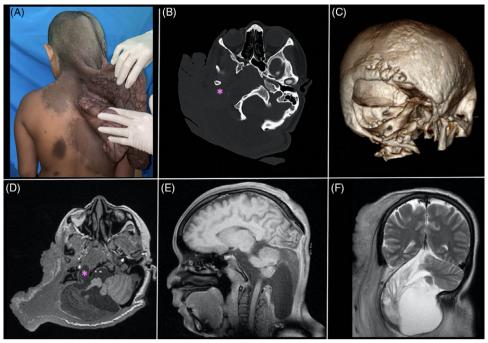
(A) View of the patient from the back, showing a large cutaneous-subcutaneous lesion on the right posterior neck, shoulder, and upper back; also seen are hyperpigmented patches in the posterior trunk; (B) cranial CT, bone window, showing a calvarial defect in the right occipital area and obliteration of the right external auditory canal and adjacent bony structures (asterisk); (C) 3D reconstruction of the cranial CT showing the occipital calvarial defect and intact upper cervical vertebrae; (D) axial sections of contrast cranial MRI, T1 sequence, showing the dysplastic right cerebellar hemisphere herniating through the calvarial defect, along with dysplastic parts of the medulla and middle and inferior cerebellar peduncles. There was also a right jugular foramen meningocele extending to the right carotid space (asterisk); (E) sagittal sections of cranial MRI, T1 sequence, showing the inferior extent of the encephalocoele down to the soft tissues at the C4 spinal level; (F) coronal sections of cranial MRI, T2 sequence, showing the dysplastic right cerebellum within the encephalocoele. These cranial imaging findings were seen in the background of a large, fungating, multilobulated, mildly enhancing soft tissue lesion in the cutaneous-subcutaneous right hemicalvarium, right auricular-periauricular, right lateral, anterior, and posterior neck regions, right shoulder, and right upper back.
